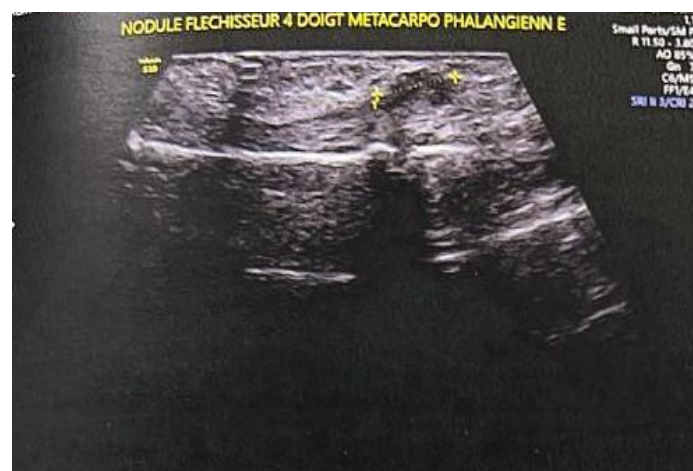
Ultrasound findings showing a well-defined, heterogeneous hypoechoic fibrous nodule, with superficial adherence to the underlying flexor tendon
